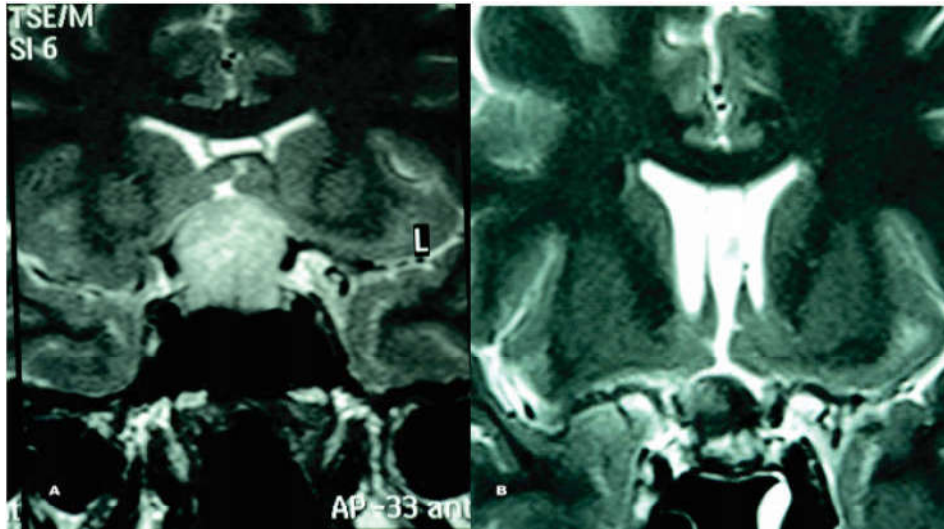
MRI Brain coronal section, Inset A- preoperative scan showing pituitary macroadenoma and Inset B- postoperative scan, showing complete excision done through endoscope assisted transphenoidal (EATS) approach
